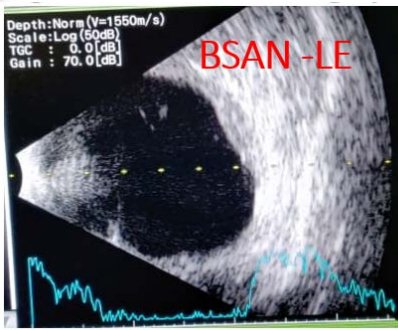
LE - ultrasonography
